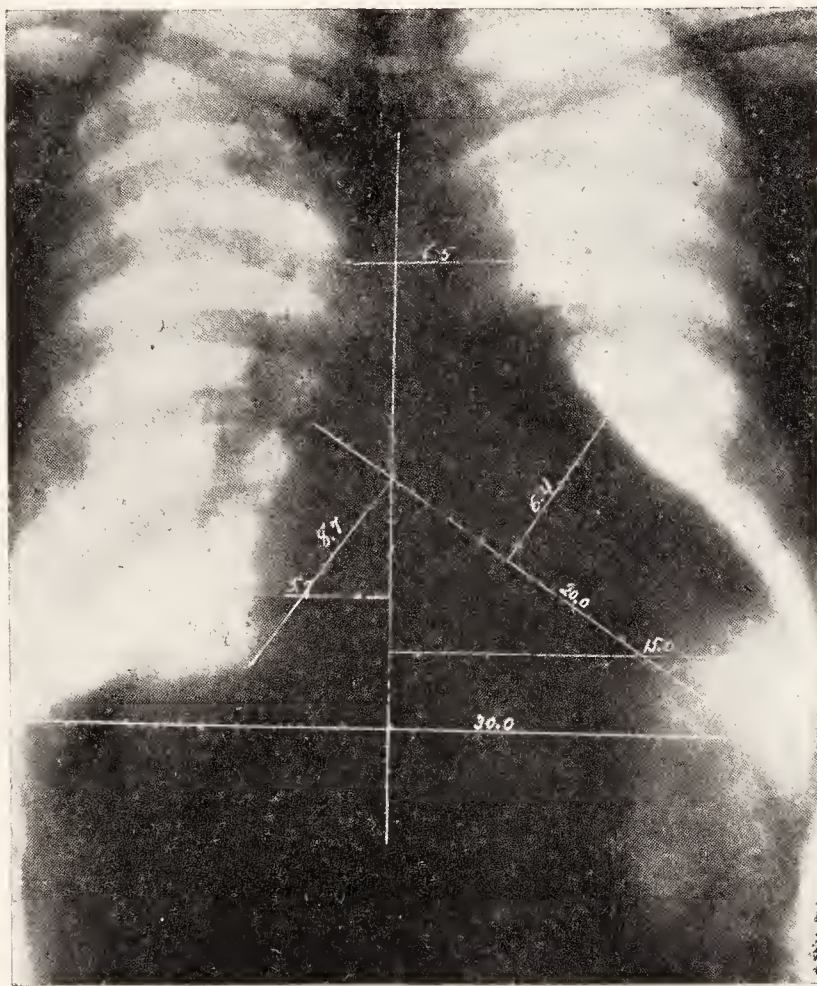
Necropsy 4327. Hypertrophy and dilatation of the heart, primary. Weight 703 grams. Mural thrombi in the right auricular appendix and the left ventricle. X-ray shows the heart shadow very much enlarged, especially to the left. Region of the right auricle also somewhat prominent. Enlargement appears somewhat symmetrical and is more suggestive of dilatation than of hypertrophy. Supracardiac shadow not abnormal. (Roentgenological Department, Massachusetts General Hospital.)
